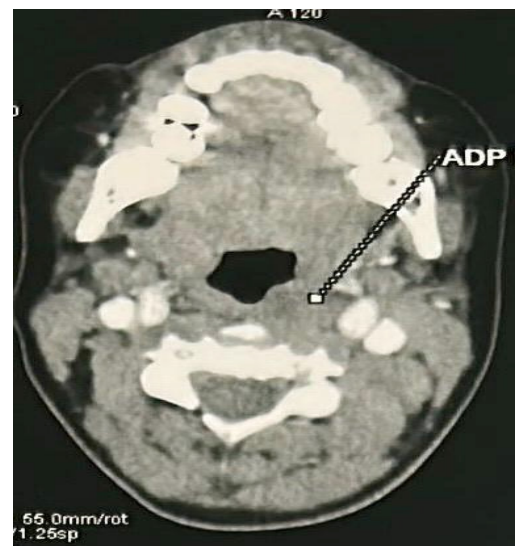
Follow-up cervico-thoracic CT scan showing regression of the retropharyngeal lymph node without residual necrosis.
